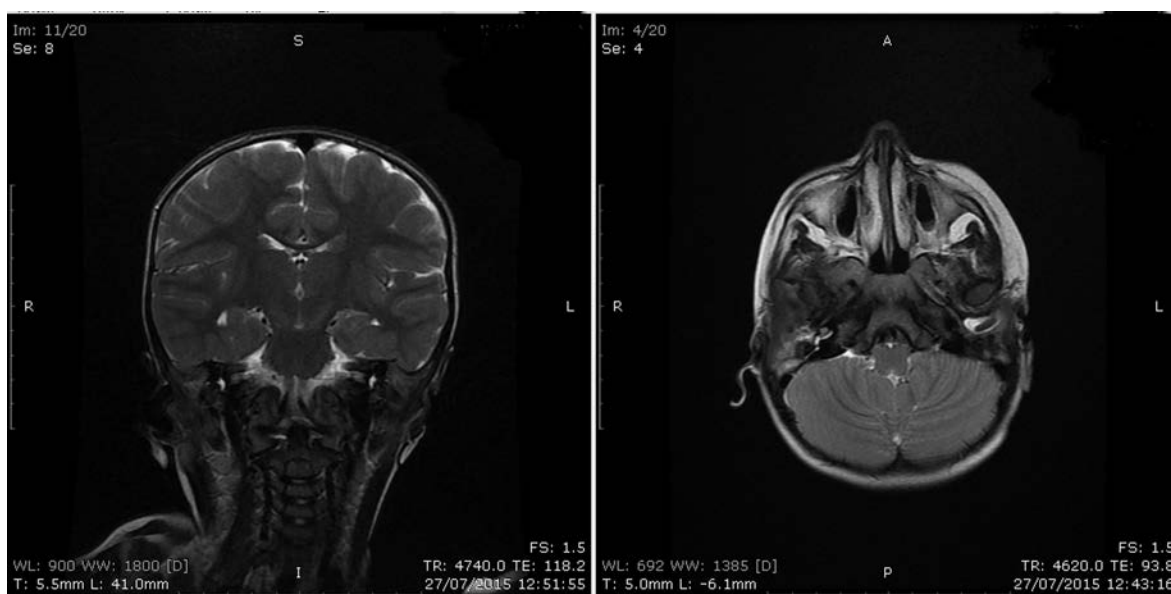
Coronal T2 weighted image also demonstrates destruction of the tegmen tympani with minimal soft tissue extension to the middle cranial fossa (left). Axial and coronal T2 weighted MR images reveal fluid and soft tissue filling the mastoid air cells bilaterally, greater on the right. The soft tissue extends to the tympanic cavity bilaterally and to the subcutaneous tissue on the left. The integrity of temporal bones and the borders of the mass lesion could not be determined (right).
